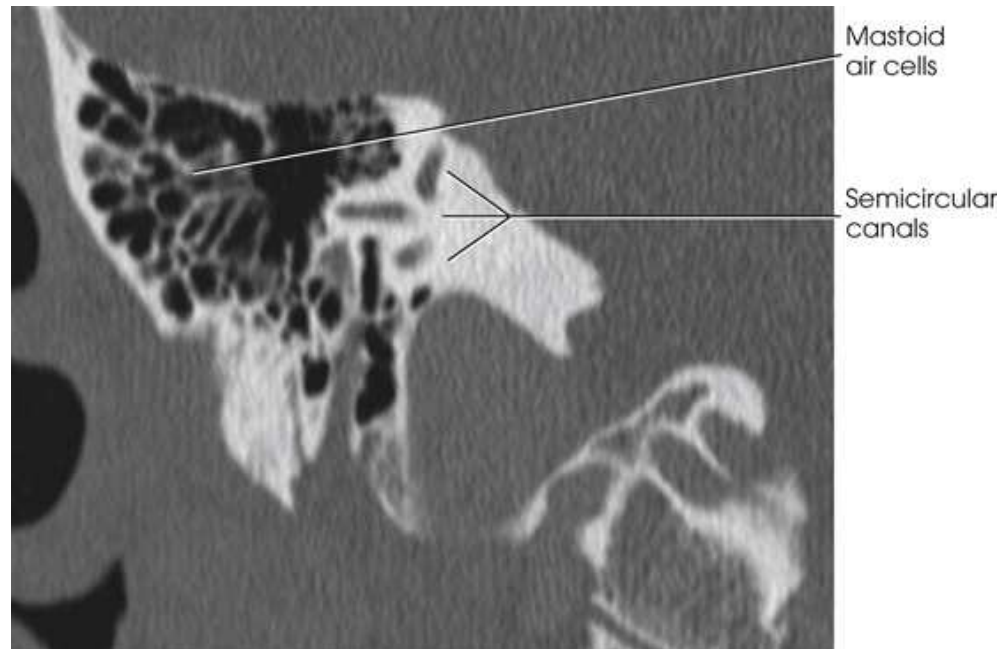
Coronal CT scan of petromastoid portion of temporal bone showing semicircular canals and mastoid air cells. Courtesy Karl Mockler, RT[R].
